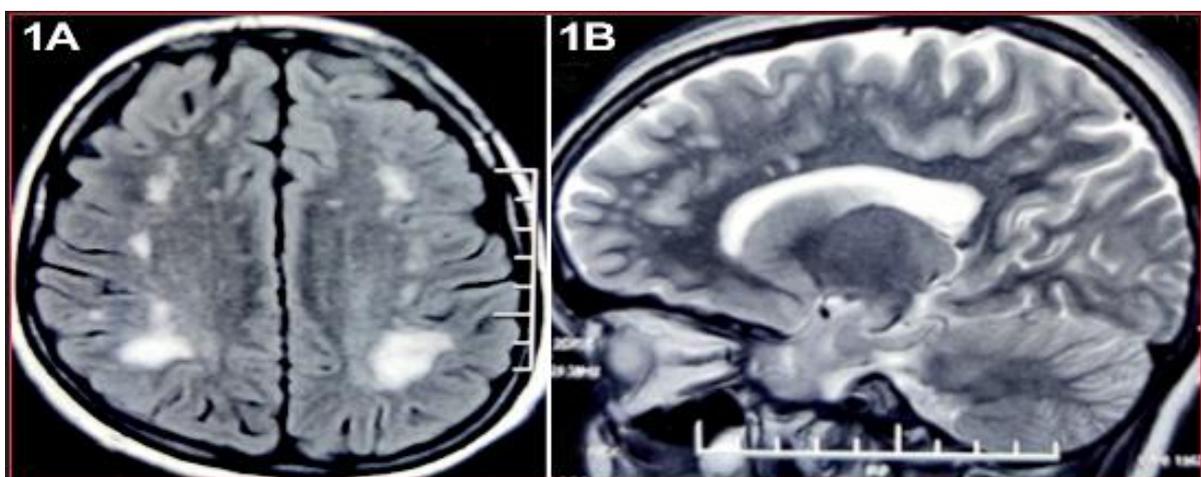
MRI brain showing symmetric subcortical hyperintensities in FLAIR sequence (A) and pericallosal snowball appearance T2 hyperintensities in sagittal view (B)
